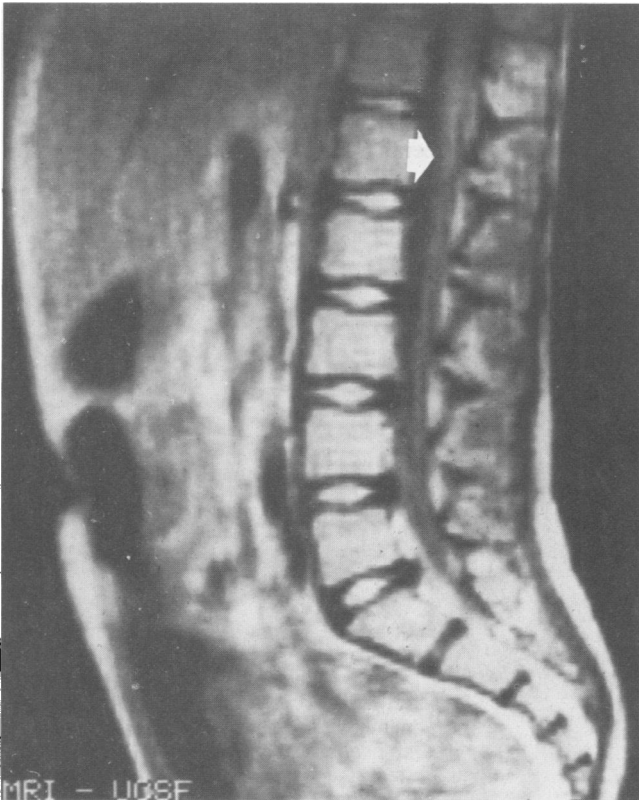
Magnetic resonance (MR) imaging produces a sharp contrast difference between the nucleus pulposus (high intensity) and the annulus fibrosus (low intensity) and further produces a clear delineation of the spinal cord (arrow) in the subarachnoid space. Myelography using MR imaging does not require contrast medium instillation.
